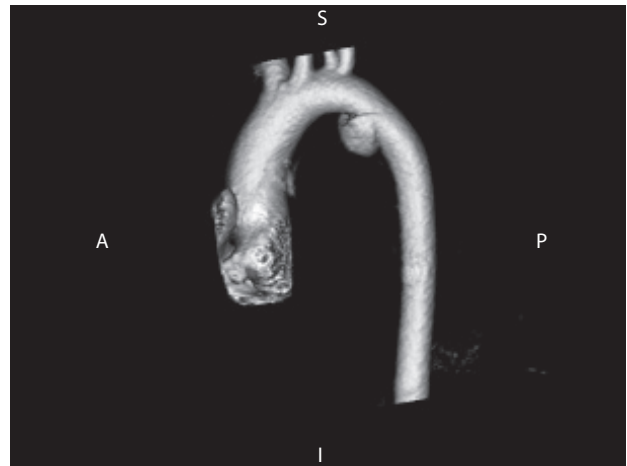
Three-dimensional reconstruction of the computed tomographic angiogram of the Figure 13.3 patient showing the grade III traumatic thoracic aortic injury just distal to the subclavian artery. Note also the anomalous aortic origin of the left vertebral artery from the aortic arch, just proximal to the left subclavian artery. A, anterior; S, superior; P, posterior; and I, inferior.
